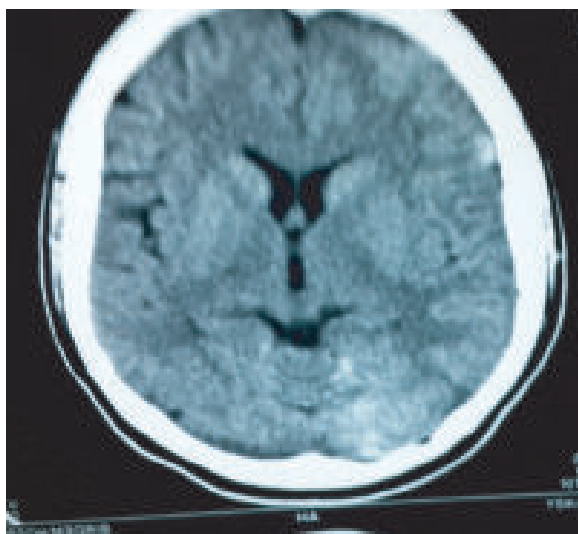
CT scan of brain showing subarachnoid haemorrhage
